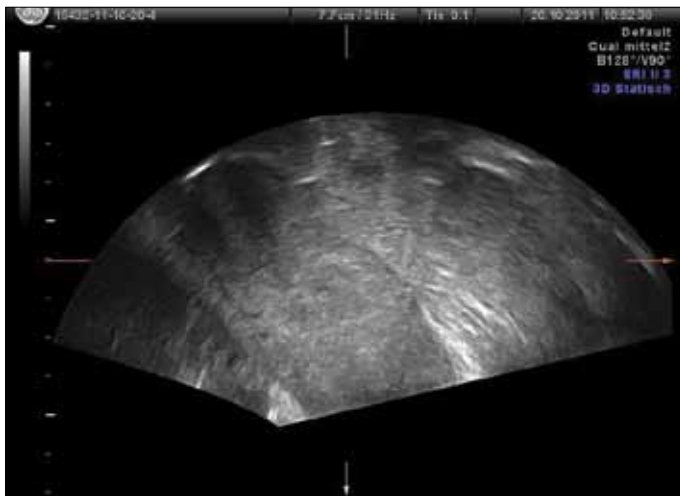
Sagittal transvaginal two dimensional sonography, showing a diffusely enlarged cervix with heterogeneous echogenicity. The tumor margins are clearly delineated
